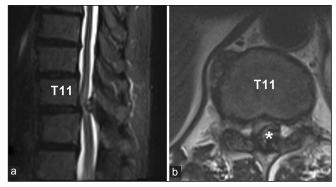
(a) Lateral and (b) axial thoracic magnetic resonance imaging scan with and without gadolinium contrast at T11-12 indicating the presence of a large left posterior synovial cyst (asterisk) causing severe spinal cord compression. There is underlying edema (myelomalacia) at T11-12.
